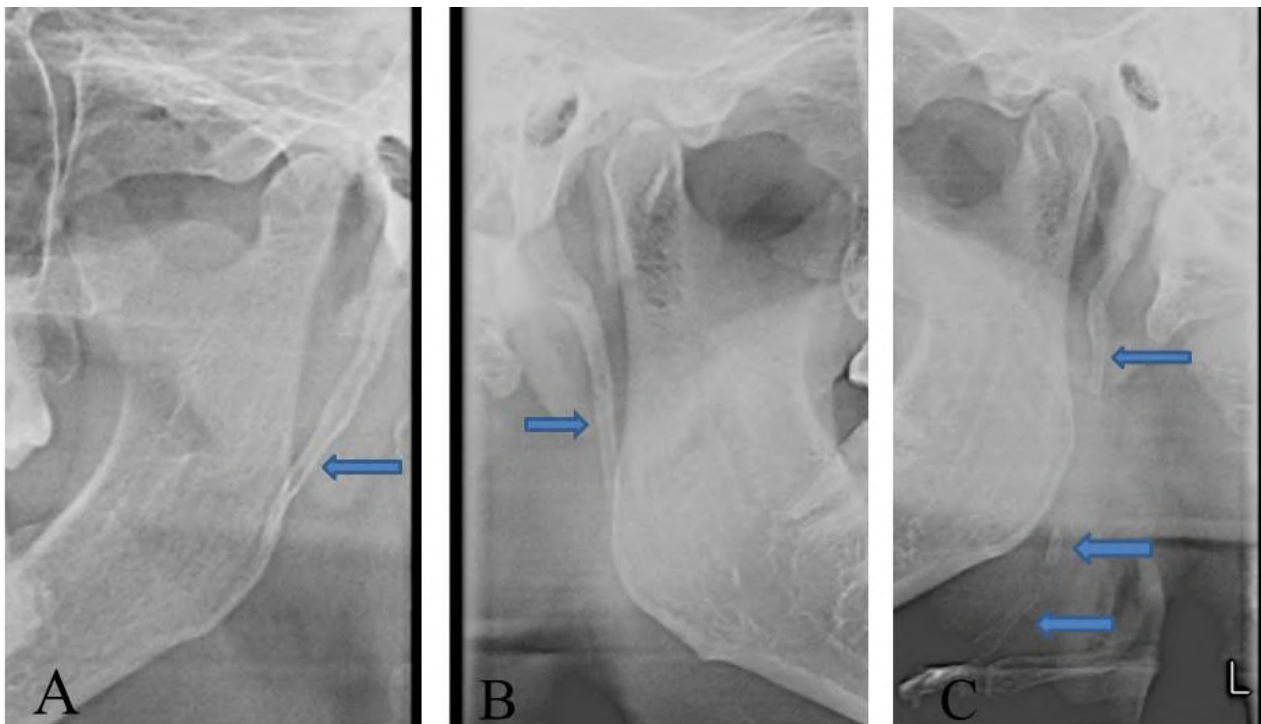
Digital panoramic radiograph showing Langlais type of elongated styloid process. A: Type I. B: Type II. C: Type III.
